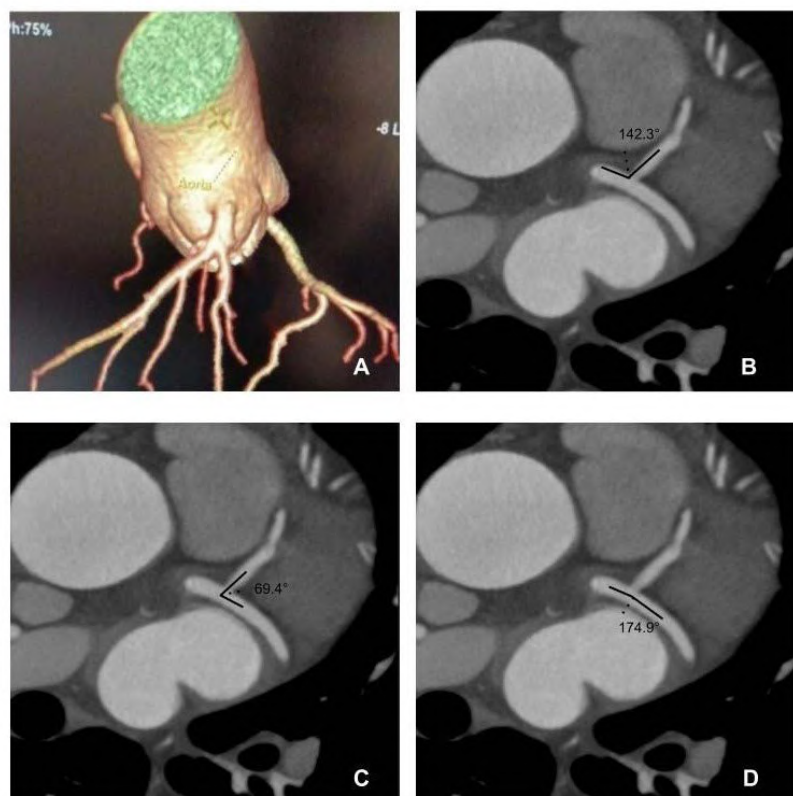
Coronary bifurcation angles on computed tomography images.
